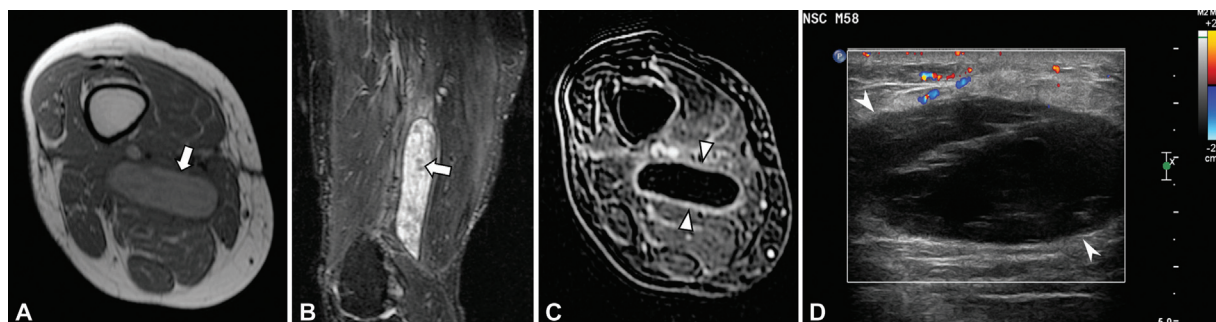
A 48-year-old woman with posterior thigh mass (arrows) 3 months following a fall. The mass is hyperintense to muscle on the (A) axial T1 fat-suppressed magnetic resonance (MR) image and heterogeneously hyperintense on the (B) sagittal short-tau inversion recovery (STIR) MR image. On the (C) postcontrast subtraction image, there is only thin peripheral enhancement (arrowheads) consistent with a hematoma. (D) Color Doppler image shows a heterogeneous hypoechoic mass (pointed arrows) with peripheral vascularity.
